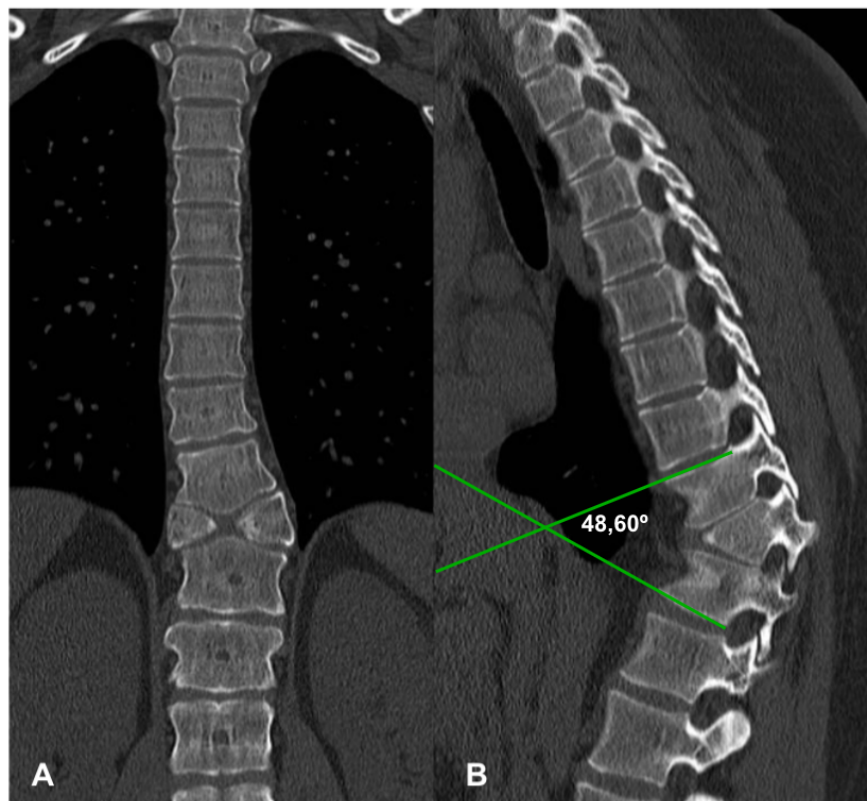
CT scan of the dorsal spine, with coronal (A), and sagittal (B) section with a T10 hemivertebra abnormality with a butterfly morphology.
